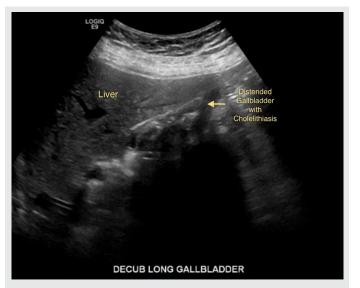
Ultrasound of the right upper quadrant. The figure shows a distended gallbladder in a decubitus long gallbladder view with cholelithiasis present.
